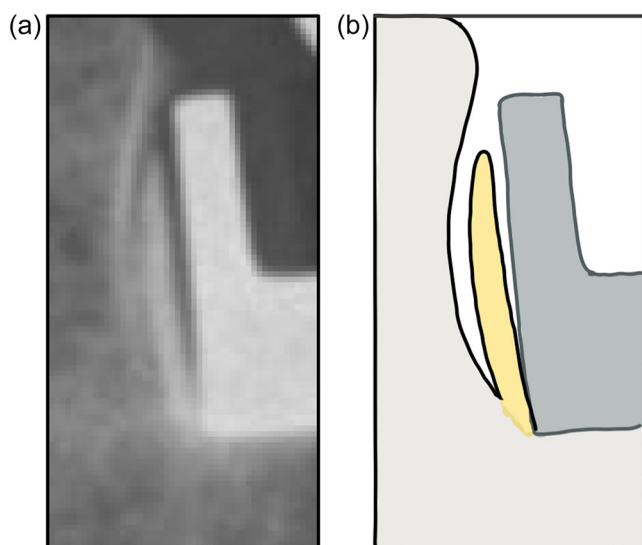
(a, b) Bone growth found in some radiographs where fixation to the tibial wall is poor fixation ratio (<20%). The feature is radiographically characterised as a generally hemilenticular opacity between the implant and sclerosed vertical bone surface. (a) Radiograph of a cementless implant; (b) graphical representation with hemilenticular opacity highlighted in yellow.
